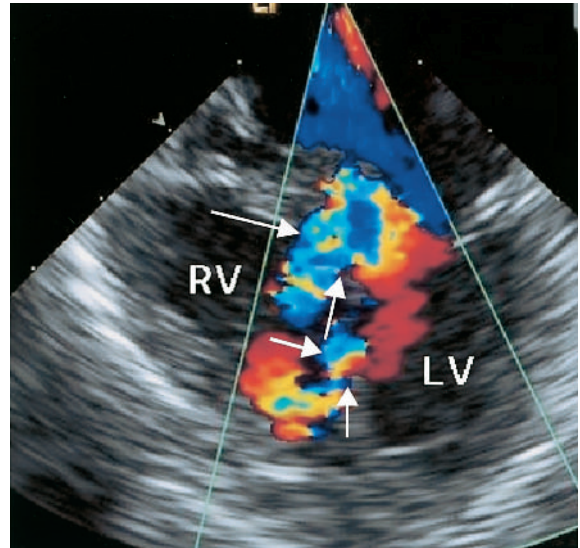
(e) Muscular ventricular septal defects. Color Doppler interrogation of the muscular septum in the four-chamber view documents multiple levels of ventricular shunting.
